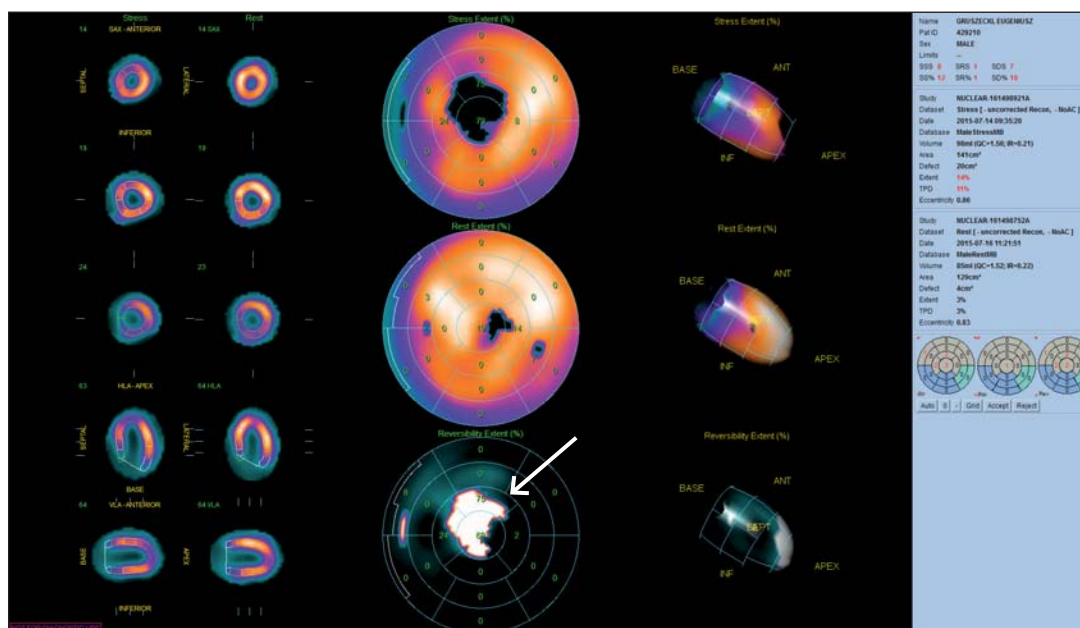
Myocardial perfusion SPECT study viewed in slices and polar maps under stress and rest. Polar maps show perfusion, defect extent, wall thickening, and segmental scoring of perfusion defect severity. Stress perfusion defect in the apex and, majority of which significantly improves (reverses) in rest study (arrow). Masses of one or more stress defects and reversible portions of defects are automatically tabulated, along with stress total severity score. SSS – stress scores; SRS – rest scores; difference scores. Software – Emory Cardiac Toolbox.
